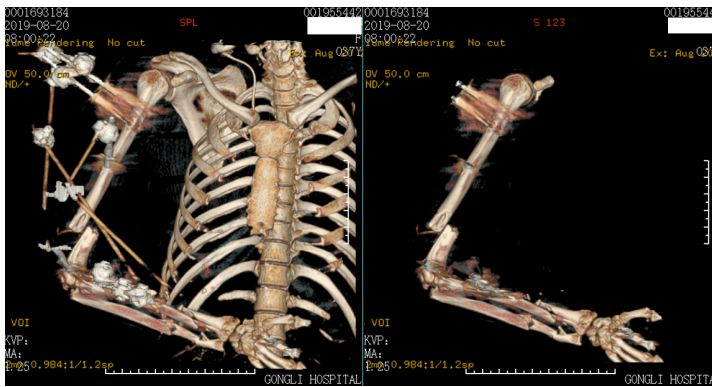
Three-dimensional computed tomography scans of the patient with external fixators.
